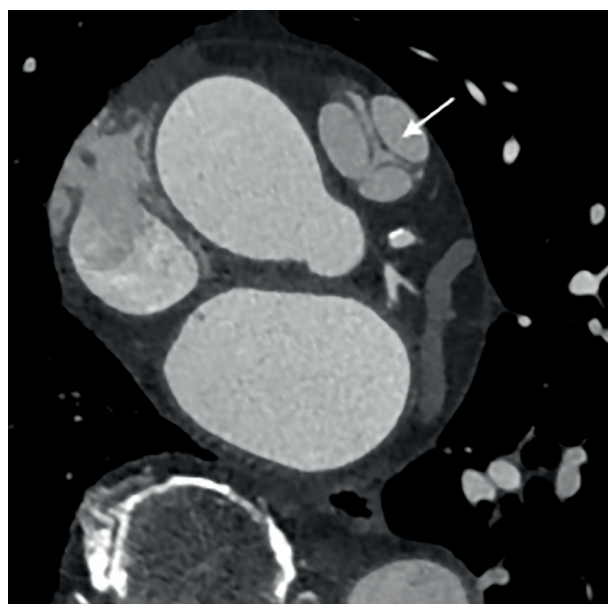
Cardiac computed tomography: multiplanar reconstruction, four-chamber view at diastole; enlargement of the right-sided chambers and thickening of the tricuspid valve and subvalvular apparatus (the arrow)
